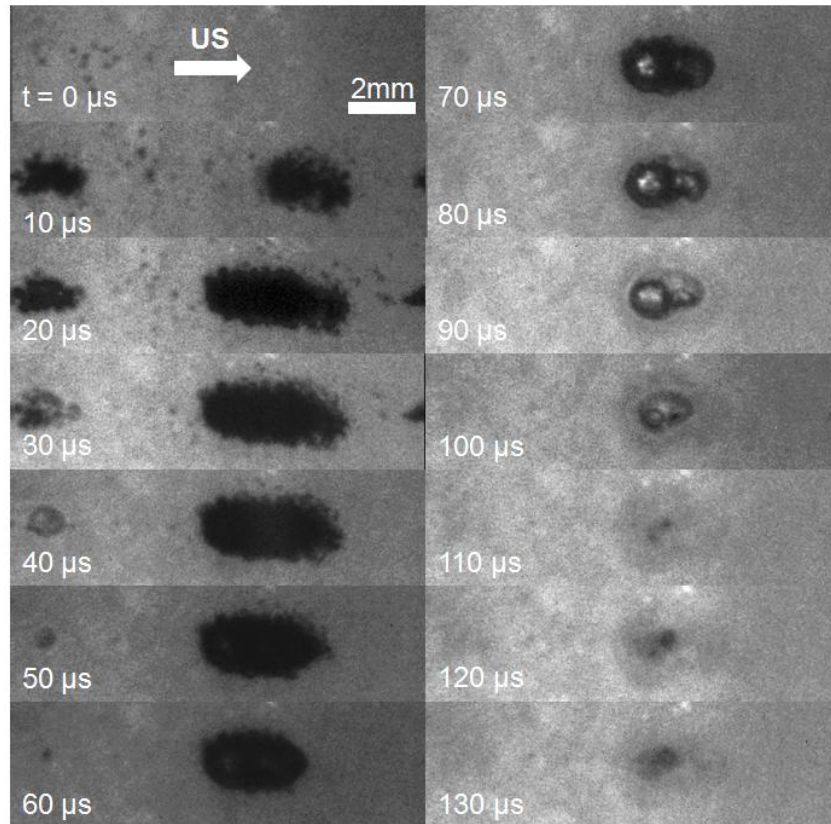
Images captured by the high-speed camera during a single ultrasound pulse. Ultrasound propagation is from left to right. The pulse arrives on the left at $0 \mu\text{s}$ and passes through the focus between $0\text{-}20 \mu\text{s}$. The bubble cloud generated during the pulse then collapses $110 \mu\text{s}$ after ultrasound exposure.
